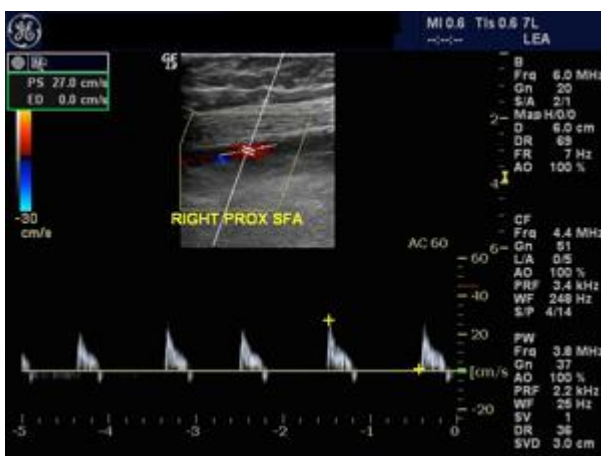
Color and Spectral Doppler image of Right Proximal Superficial Femoral Artery
